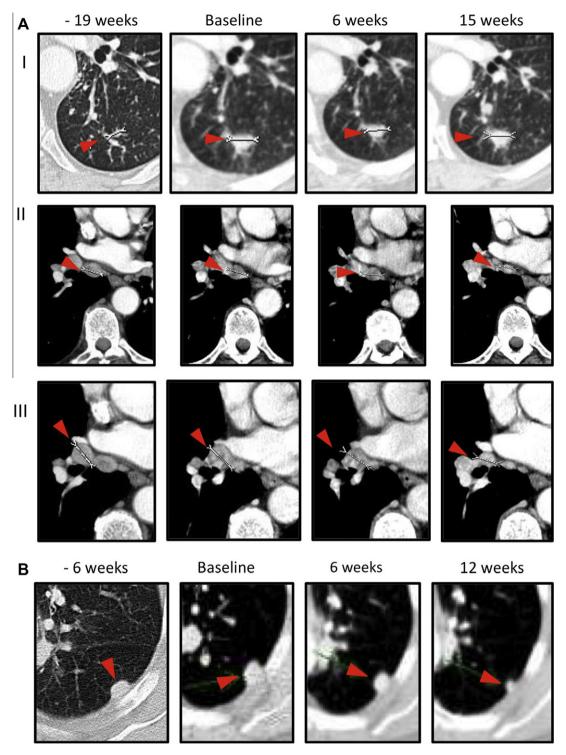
Computed tomography documentation of responses observed in two RCC patients. (A) CT images of stabilisation of a previously progressing lung lesion (I: pre-baseline 7 mm, baseline 13 mm, first TA 13 mm, second TA 13 mm) and of minor responses regarding a right hilar lymph node (II: pre-baseline 16 mm, baseline 18 mm, first TA 18 mm, second TA 12 mm) and a subcarenal lymph node (III: pre-baseline 18 mm, baseline 21 mm, first TA 19 mm, second TA 15 mm) of patient no. 21 (best response –14.6%; previous treatment with IL2) are indicated by red arrowheads. CT images were taken 19 weeks before baseline, at baseline and at later time-points indicated in figure. (B) CT images of minor responses of a lung lesion, indicated by the red arrowheads, of patient no. 45 (best response –3%; previous treatment with interferon monotherapy) are shown. CT images were taken at baseline and at later time-points indicated in figure.
